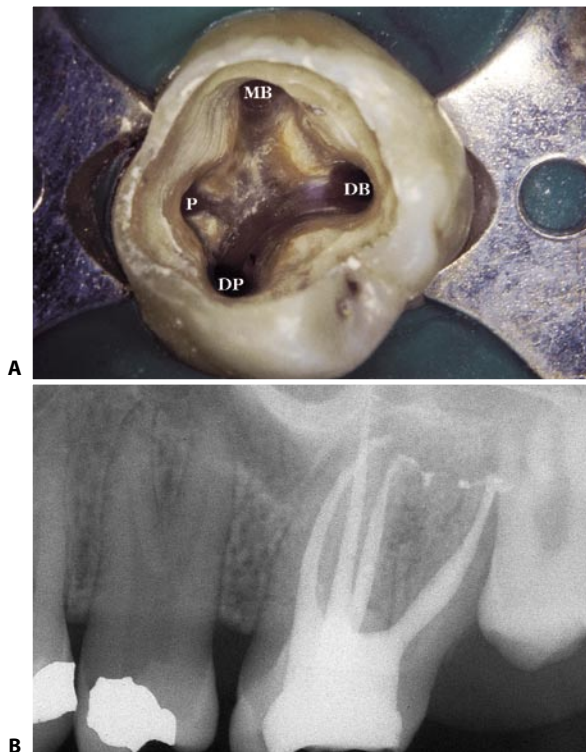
A. Access cavity of an upper left first molar with two palatal canals in two distinct roots: P, palatal canal; MB, mesiobuccal canal; DB, distobuccal canal; DP, distopalatal canal. B. Postoperative radiograph of the same tooth.
